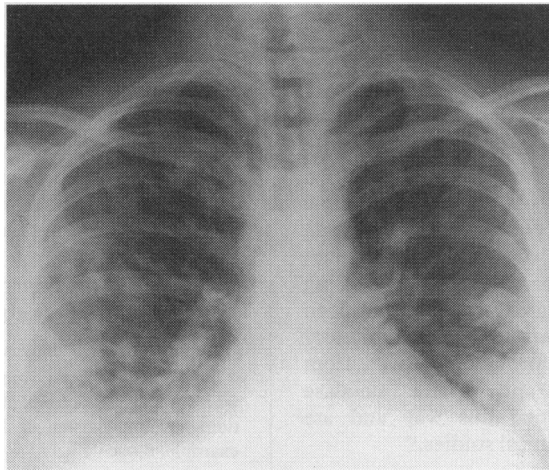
Radiograph showing staphylococcal pneumonia as complication of influenza
